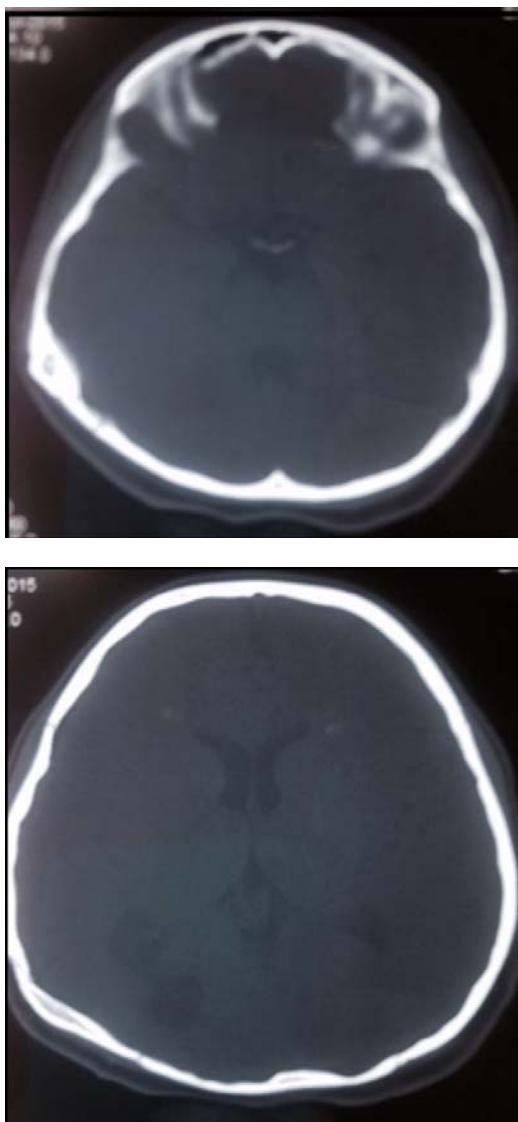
Follow-up- A) Clinical-photograph after 10years B) Plain CT with bone window showing Good - osteosynthesis, C) Plain CT soft tissue window showing normal brain & ventricles bilaterally.
